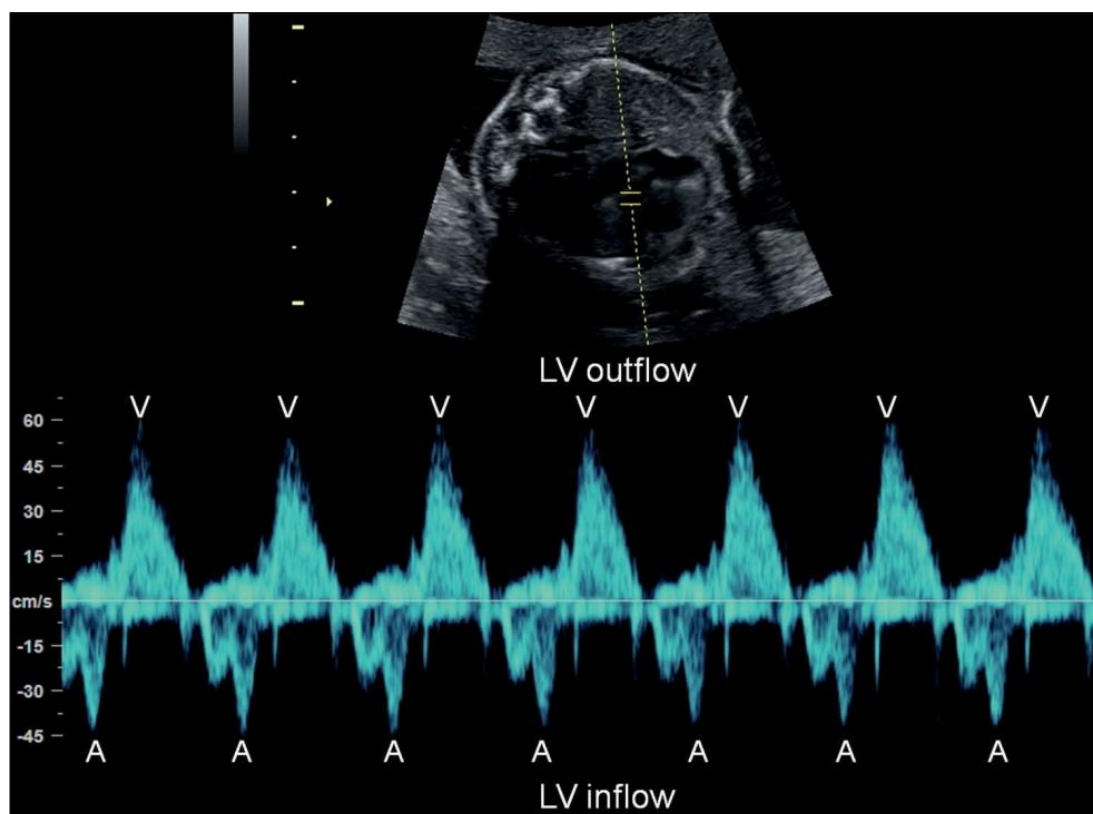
Pulsed wave Doppler positioned through the left ventricular (LV) outflow tract and the mitral valve demonstrating normal sinus rhythm. The mitral valve inflow waveform represents atrial contraction (A) with ventricular contraction represented by the outflow through the left ventricular outflow tract (V). 1:1 conduction can be seen representing normal sinus rhythm (Weber et al., 2011).
